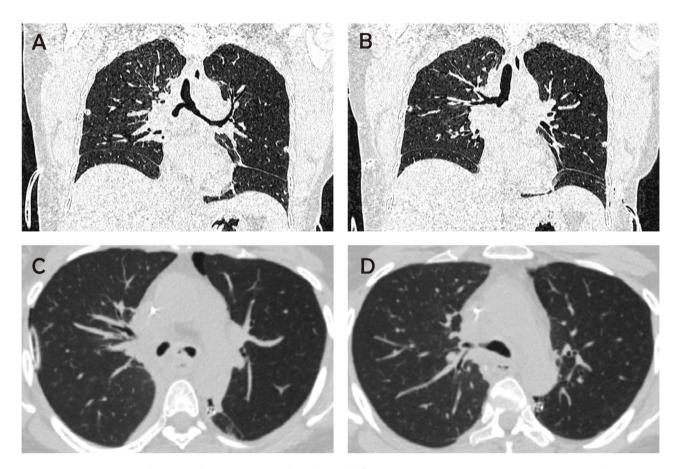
Postoperative CT scan shows that the airway between the trachea and left main bronchus is clear and intact(A, C), and the airway between the trachea and right main bronchus is also clear and intact(B, D)
